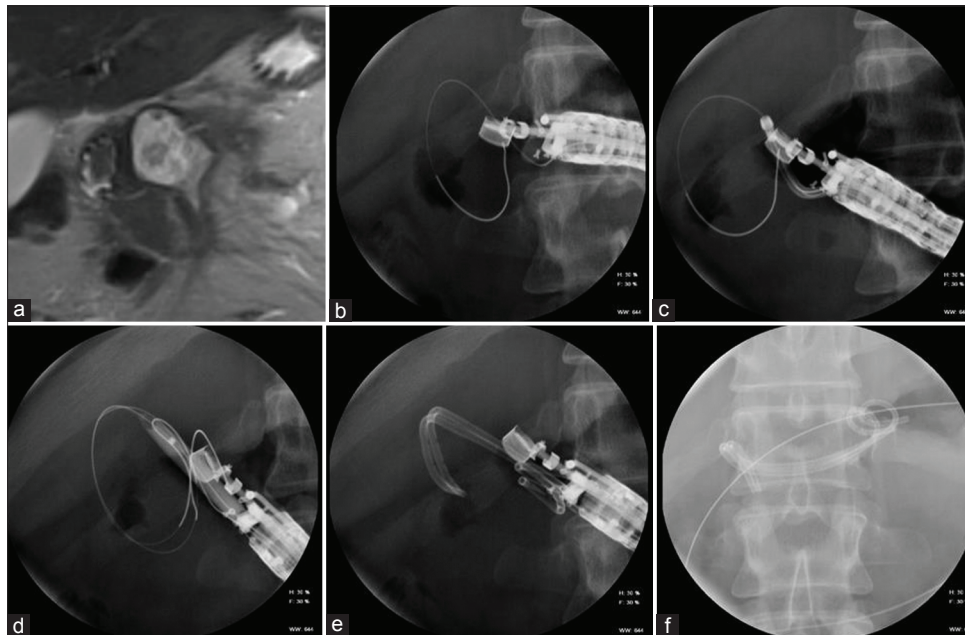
(a) A secretin-stimulated magnetic resonance cholangio-pancreatography showing a pancreatic fluid collection associated with a complete pancreatic duct disruption. (b) Using endoscopic ultrasound guidance, the pancreatic fluid collection (PFC) is punctured with an electrosurgical needle and a 0.035-inch guidewire is advanced into the collection. (c) The puncture tract is then enlarged using a cystenterostome. (d) After a second 0.035-inch guidewire has been advanced, the puncture tract is dilated using an 8 mm balloon dilator. (e) Using the guidewires, two double pigtail stents are advanced into the PFC to keep the fistula tract open. (f) After removal of the endoscope, the two double pigtail stents are seen side-by-side
